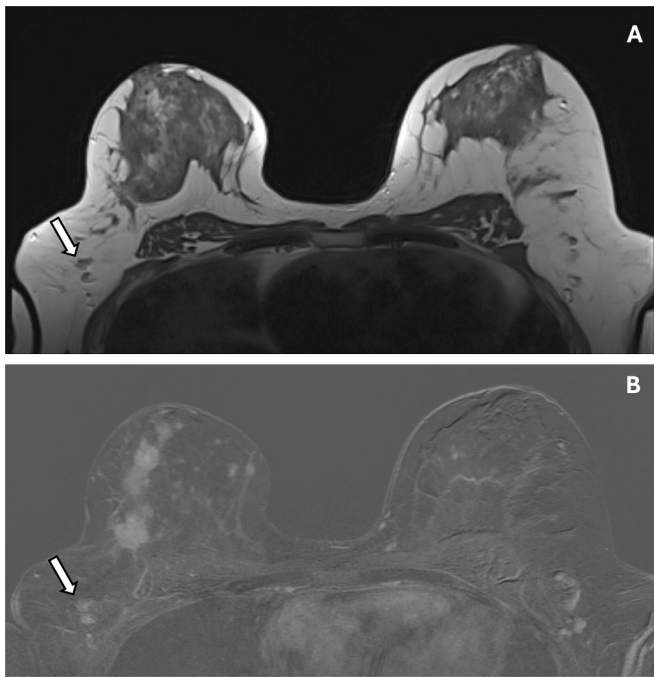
Node-RADS 3–52-year-old woman with multicentric grade 3 breast carcinoma of no special type (IBC-NST) in the right breast undergoing preoperative MRI. (A) Axial T2-weighted image shows a kidney-bean-like lymph node with irregular borders, without fatty hilum (arrow); (B) Axial contrast-enhanced T1-weighted image confirms normal size and shows heterogeneous enhancement (arrow). These features are consistent with Node-RADS 3.
